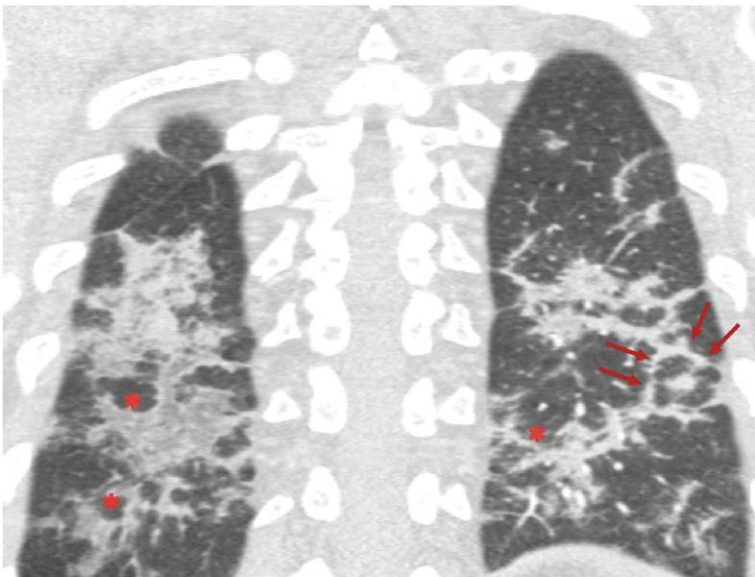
A coronal CT scan with lung window settings showing extensive bilateral organizing pneumonia with a perilobular distribution (asterisk) and with a target sign in the left lower lobe (arrows), characterized by peripheral opacity and a central nodular area.
